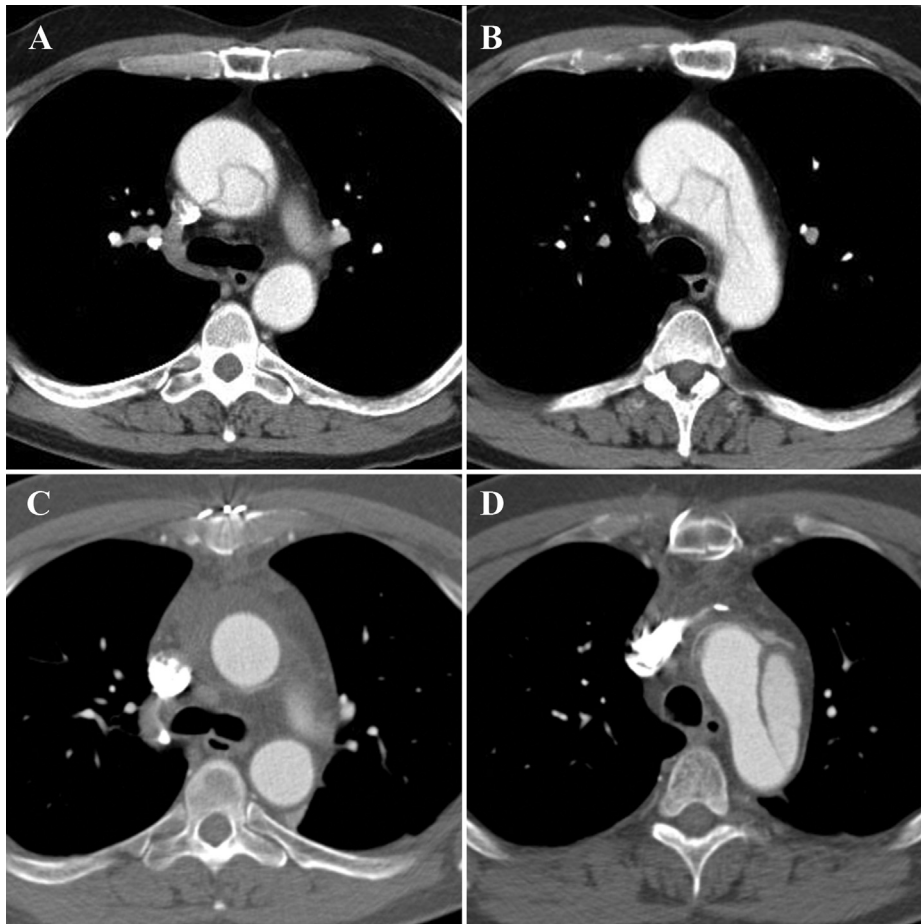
(A, B) Preoperative and (C, D) postoperative axial computed tomography angiography images demonstrating ascending aorta and arch dissection extending to the level of the aortic isthmus. (C) After replacement of the ascending aorta, (D) there is still a patent false lumen in the aortic arch.
